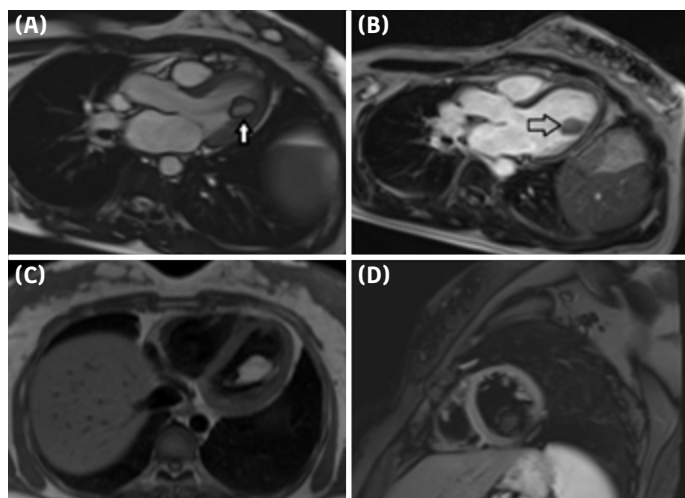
Cardiac magnetic resonance imaging: (A) Long-axis cine view. The mass is characterized by its smooth, well-circumscribed, hyperintense appearance, with evidence of origin from the papillary muscle. The presence of the "Indian ink" around the mass is also noted. (B) Late gadolinium enhancement in the long-axis cine view; (C) Hyperintense mass on transaxial T1-weighted image; (D) Hypointense mass on short-axis T2-weighted fat-suppressed image.
